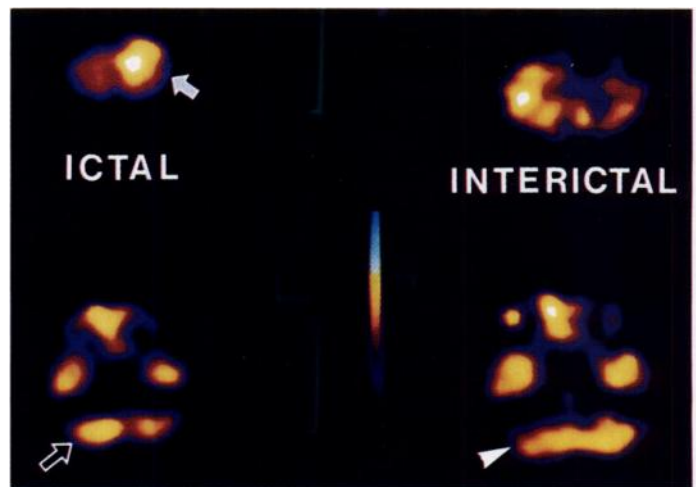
Left frontal lobe epilepsy in a 4-yr-old boy. Transaxial ictal SPECT shows increased uptake in left vertex (arrow) and right cerebellum (open arrow). Interictal SPECT demonstrates diminished uptake in epileptic focus and right cerebellum (arrowhead).
